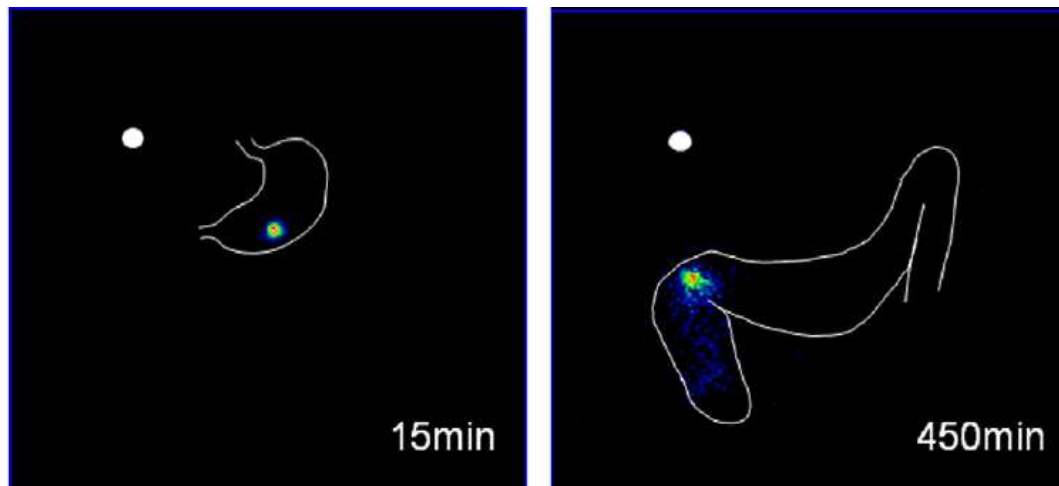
Images of the intact tablet in the stomach and the ascending colon 15 and 450 minutes, respectively, acquired by gamma scintigraphy. Taken from [79].
